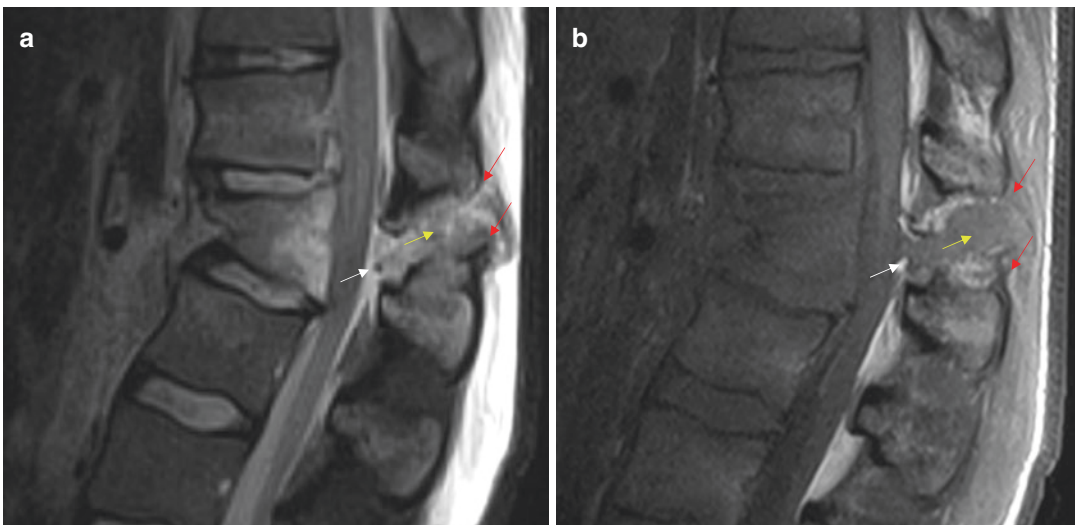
(a) Sagittal T2- and (b) sagittal T1-weighted images demonstrate ruptured free edges of the supraspinous ligament (red arrows) and interspinous ligaments (yellow arrows) at T12-L1. The LF is also ruptured (white arrows)
